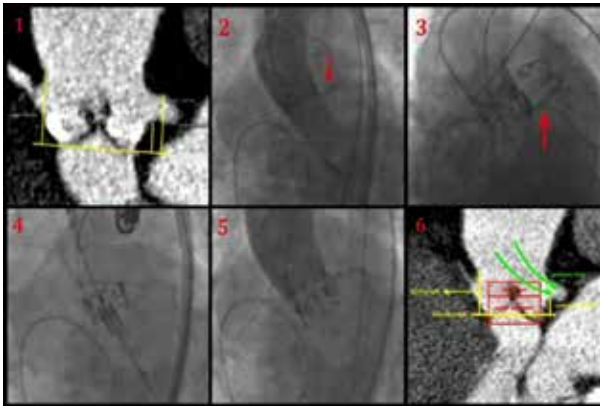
Pre-procedural evaluation by multidetector computed tomography (1); Stepwise implantation of the valve-in-valve procedure (2-6).
